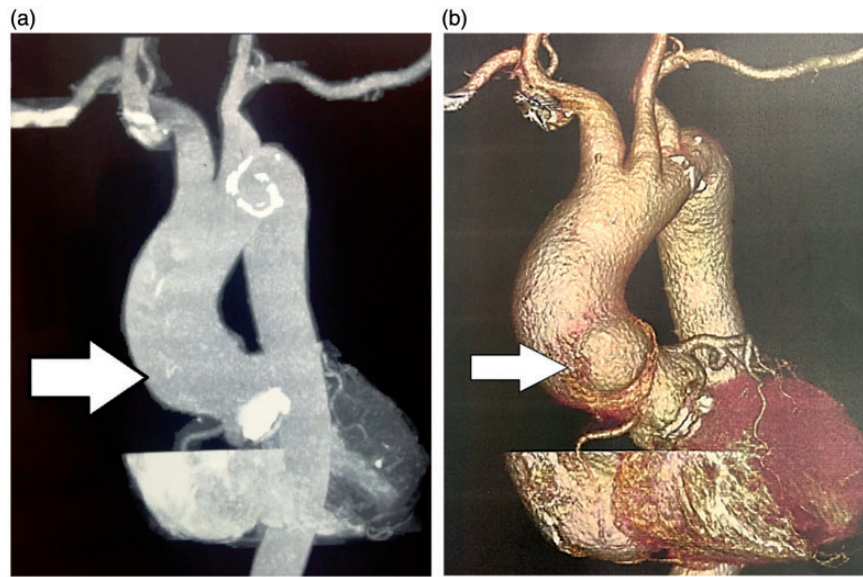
(a, b) Computed tomography angiogram at the 8-month postoperative follow-up in case 1. Arrows indicate the site of pseudoaneurysm repair.
